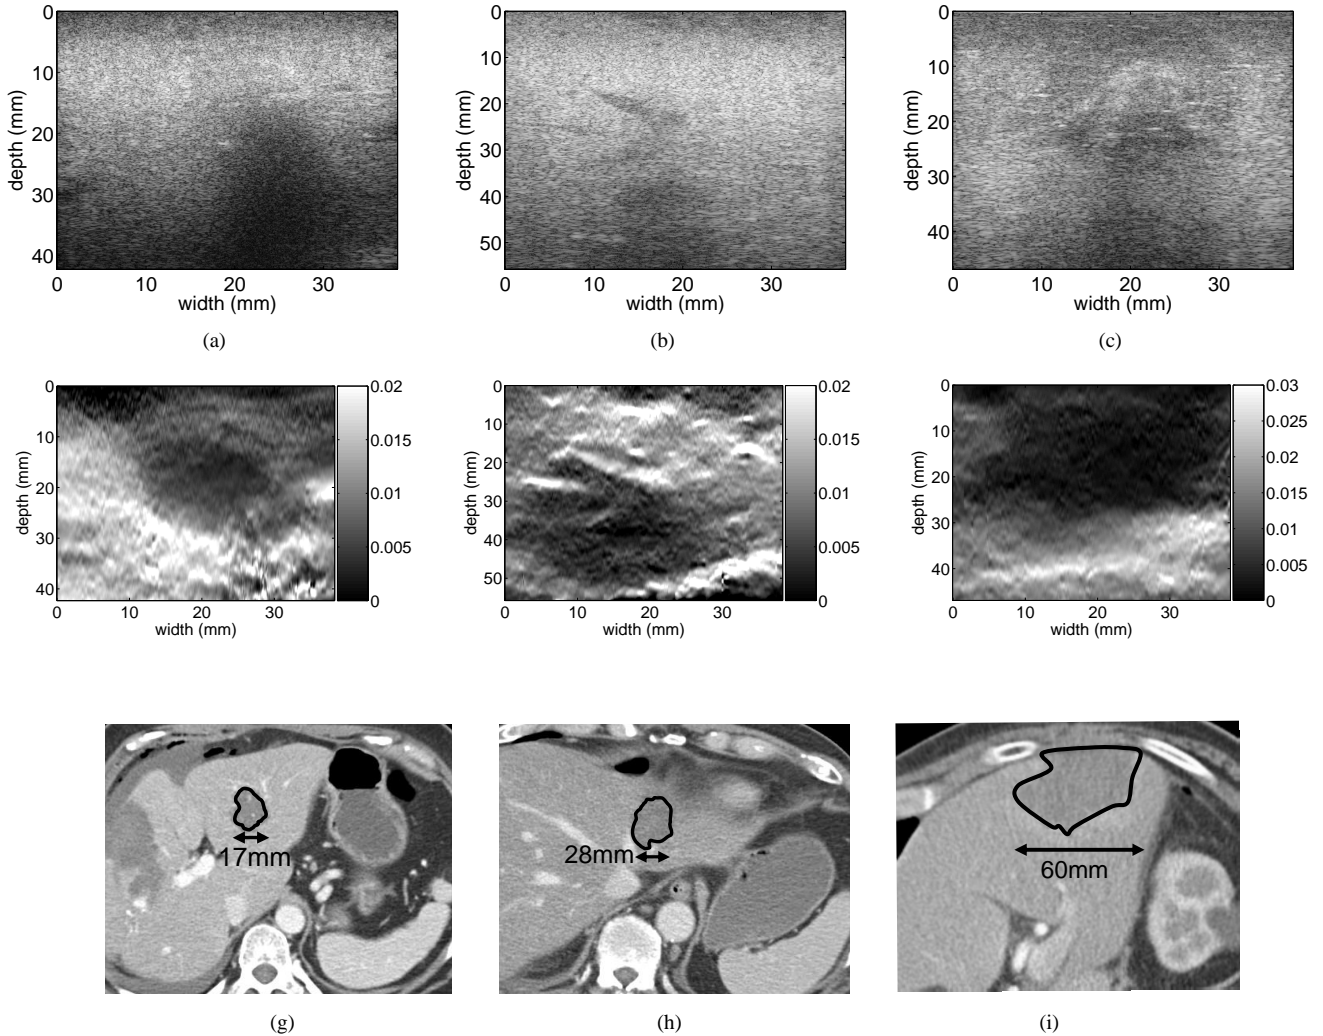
In-vivo* images of the thermal lesion produced by RF ablation therapy of liver cancer. First, second and third column correspond to the first, second and third patients. (a) - (c) B-scan after RF ablation. The shadow in (a) and (c) indicates the presence of thermal lesion. It is almost impossible to ascertain the size and position of the thermal lesion from the B-scans. (d) - (f) Strain images after RFA ablation, generated using 2D DP elastography and freehand palpation of the liver tissue. The thermal lesion is visible in dark surrounded by normal tissue in white. (g) - (i) Post-ablation CT scans, with the delineated thermal lesions (The non-unity aspect ratio in the axes of the B-mode and strain images should be considered when comparing them with the CT scans).
